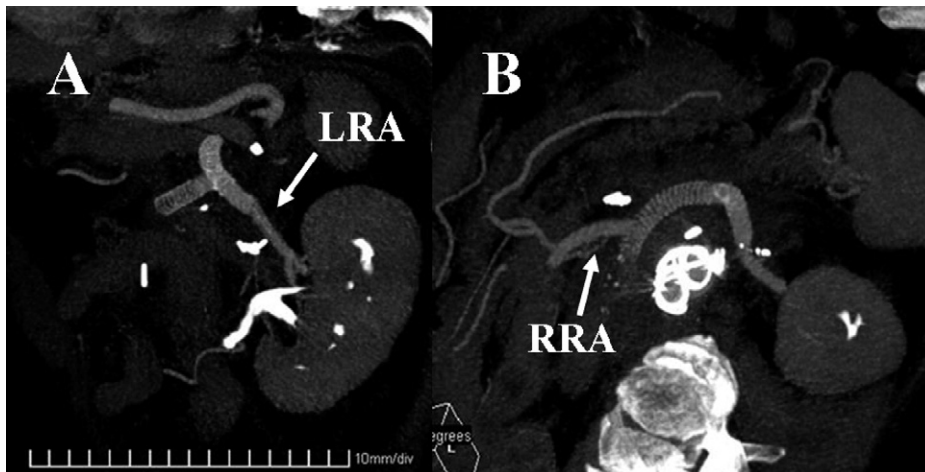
Postoperative computed tomography angiogram demonstrates revascularization of the (A) left and (B) right renal arteries with synthetic graft interposition. *LRA*, Left renal artery; *RRA*, right renal artery.
